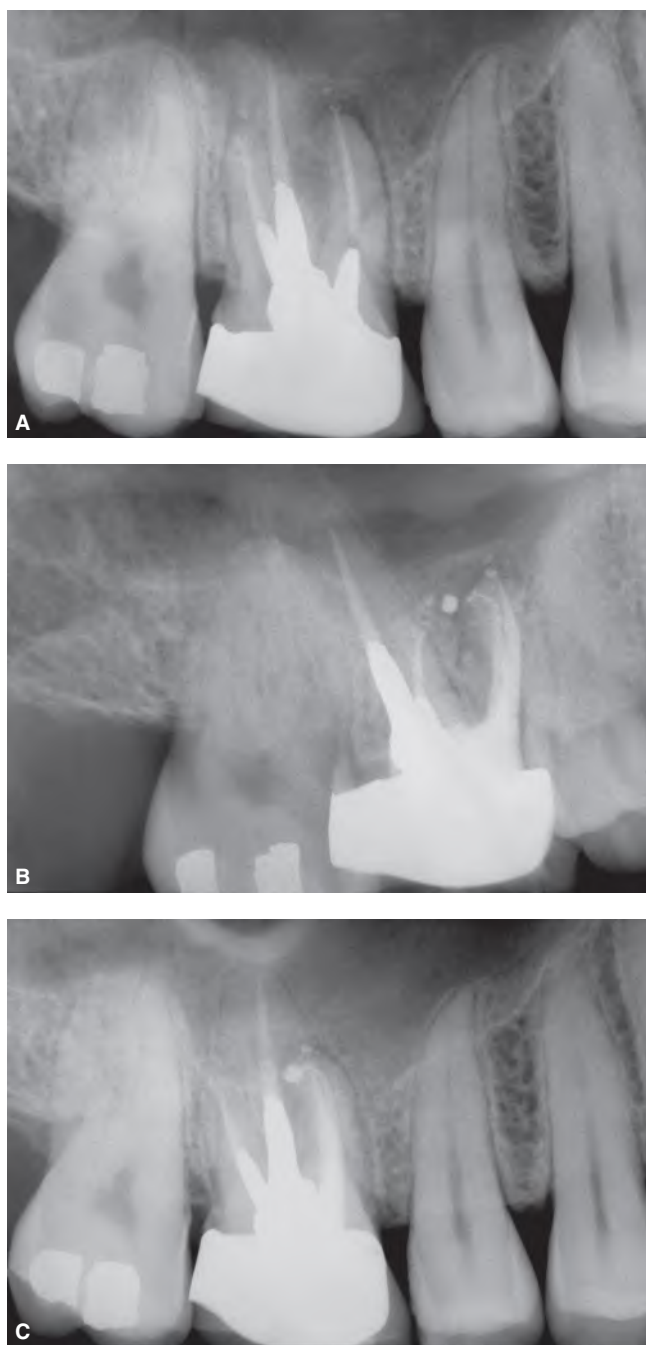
A. Preoperative radiograph reveals the MB root of the maxillary first molar is failing endodontically. Note, 3 cast posts interlocking within the pulp chamber. B. A distal angulated radiograph demonstrating the retreatment effort of the MB root. Note the identification and treatment of the MB-2 system. C. A two-year recall radiograph demonstrates excellent bony healing associated with the MB root.
